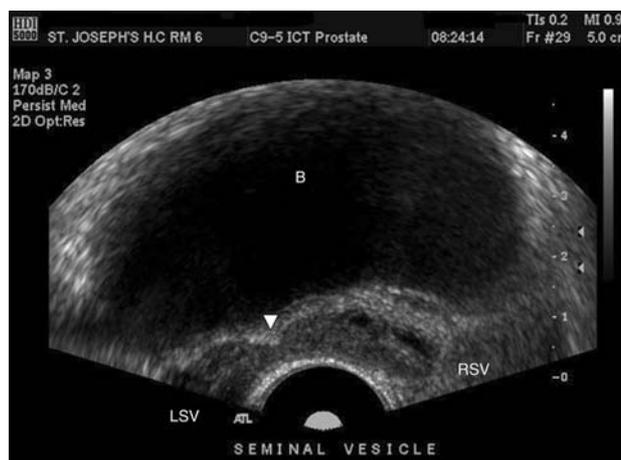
Trans rectal ultrasound image, showing the bladder (B), and the right (RSV) and left (LSV) seminal vesicles joined in the midline by an isthmus (arrow head)
